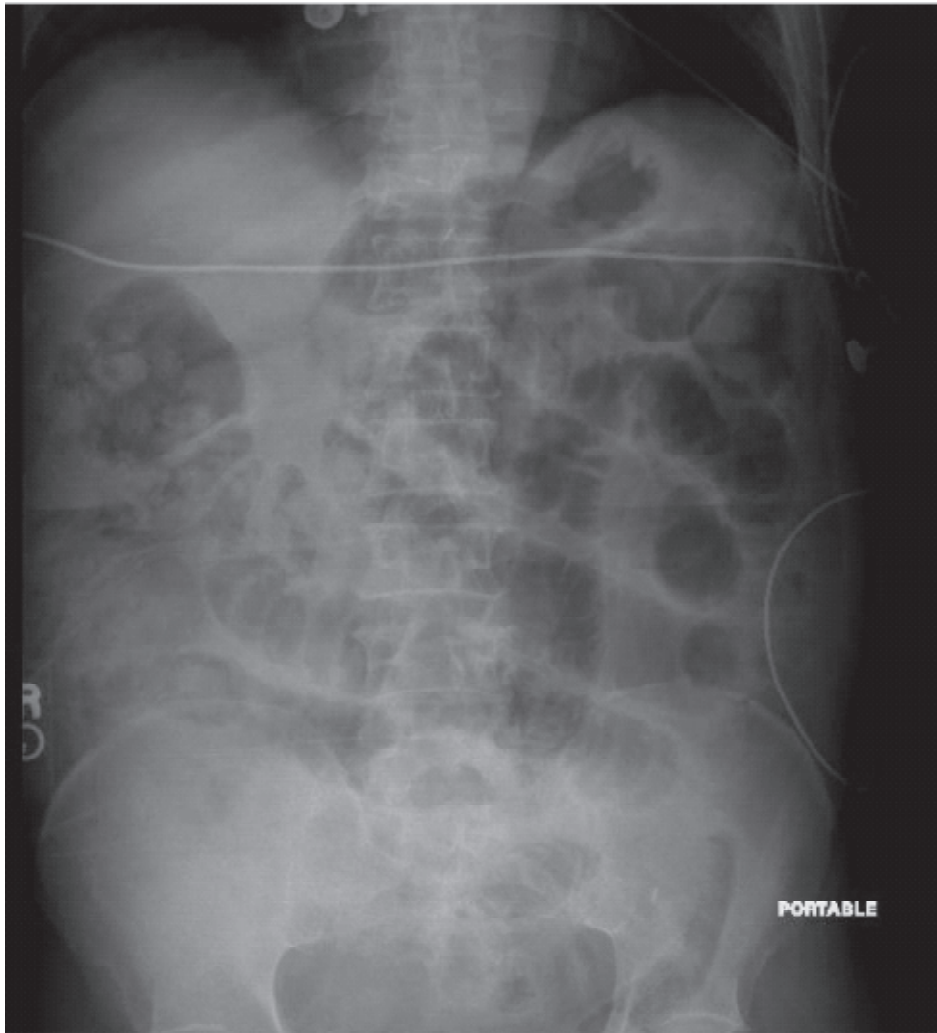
ABDOMINAL ROENTGENOGRAM
